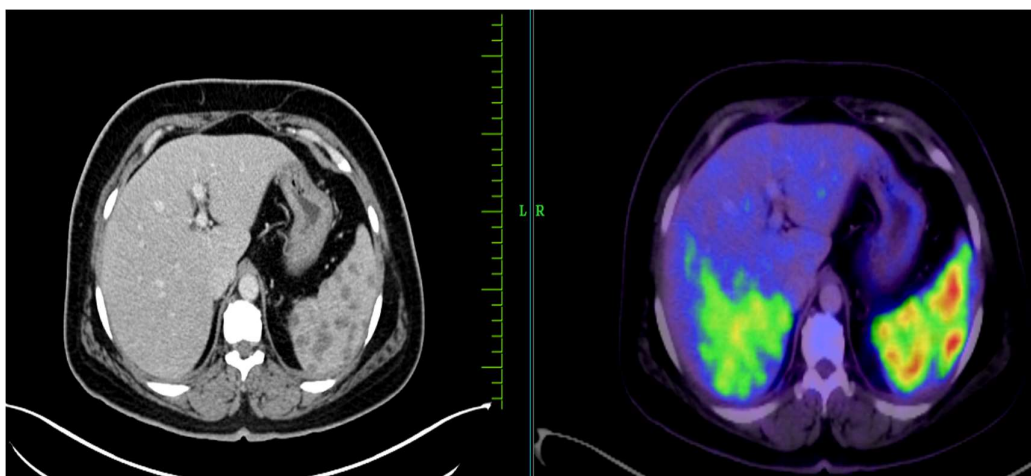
Case 2 – Hepatosplenic FDG Uptake Mimicking Lymphoma, Proven Granulomatous Disease (Hepatosplenic Sarcoidosis)
